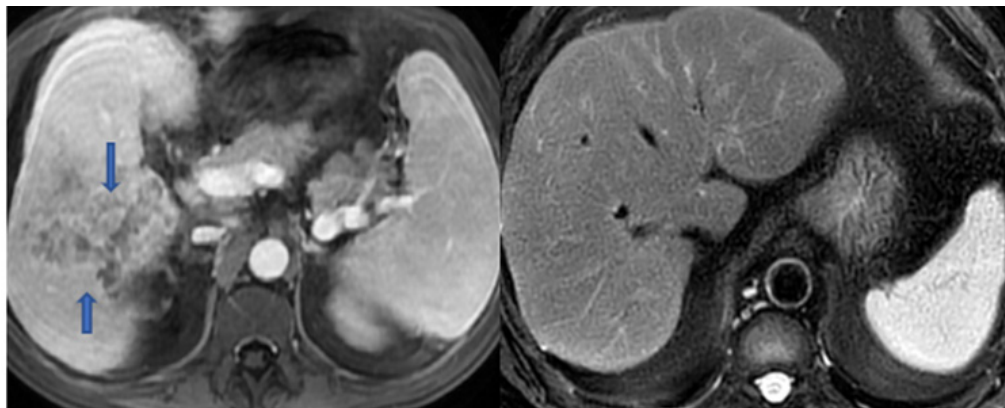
Contrast-enhanced abdominal magnetic resonance imaging (MRI) revealed a progressively enlarging hepatic lesion with ill-defined borders and internal heterogeneity, measuring approximately 15×13×7 cm (arrows). The liver was enlarged, measuring 229 mm in craniocaudal length. The spleen was also enlarged, with a longitudinal diameter of 15 cm. At the 6-month follow-up, imaging showed complete resolution of the hepatic mass and normalization of liver and spleen size.
